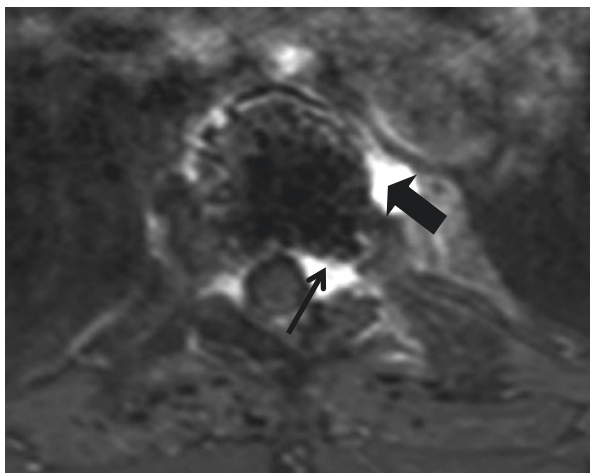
Same case as before, MR follow-up 2 years after the procedure, fast spin-echo MR image with fat suppression with contrast: it shows minimal residual of the hemangioma in the left lateral epidural side (*black arrow*) and in the left paravertebral side (*black arrowhead*)
